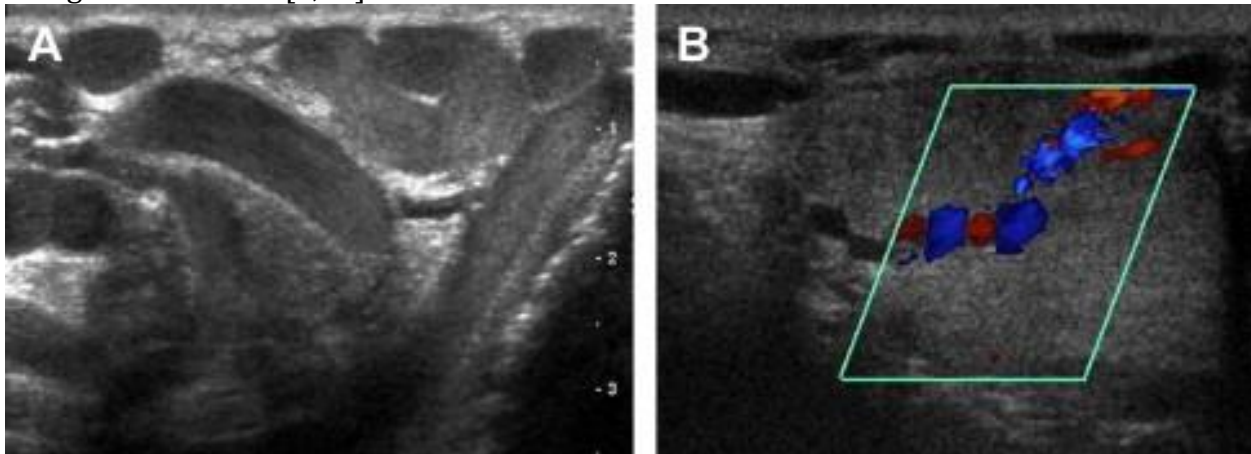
Visualization of an ultrasound image in B-mode (A) and in color Doppler mode (B).
